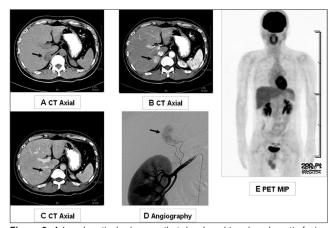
Adrenal cortical adenoma that developed in adrenohepatic fusion tissue in a 37-year-old man. Abdominal CT shows (a) a well-defined right hepatic mass (arrow) in the precontrast phase, (b) enhanced in the arterial phase, and (c) faded in the portal venous phase, which was a pathognomonic feature of primary hepatocellular carcinoma. (d) Angiographies of right inferior phrenic artery and right renal artery revealed a hypervascular tumor over right adrenal gland (arrow) unexpectedly. (e) FDG PET/CT showed normal FDG biodistribution over liver, brain, vocal cord, heart, gastrointestinal, and genitourinary systems.
